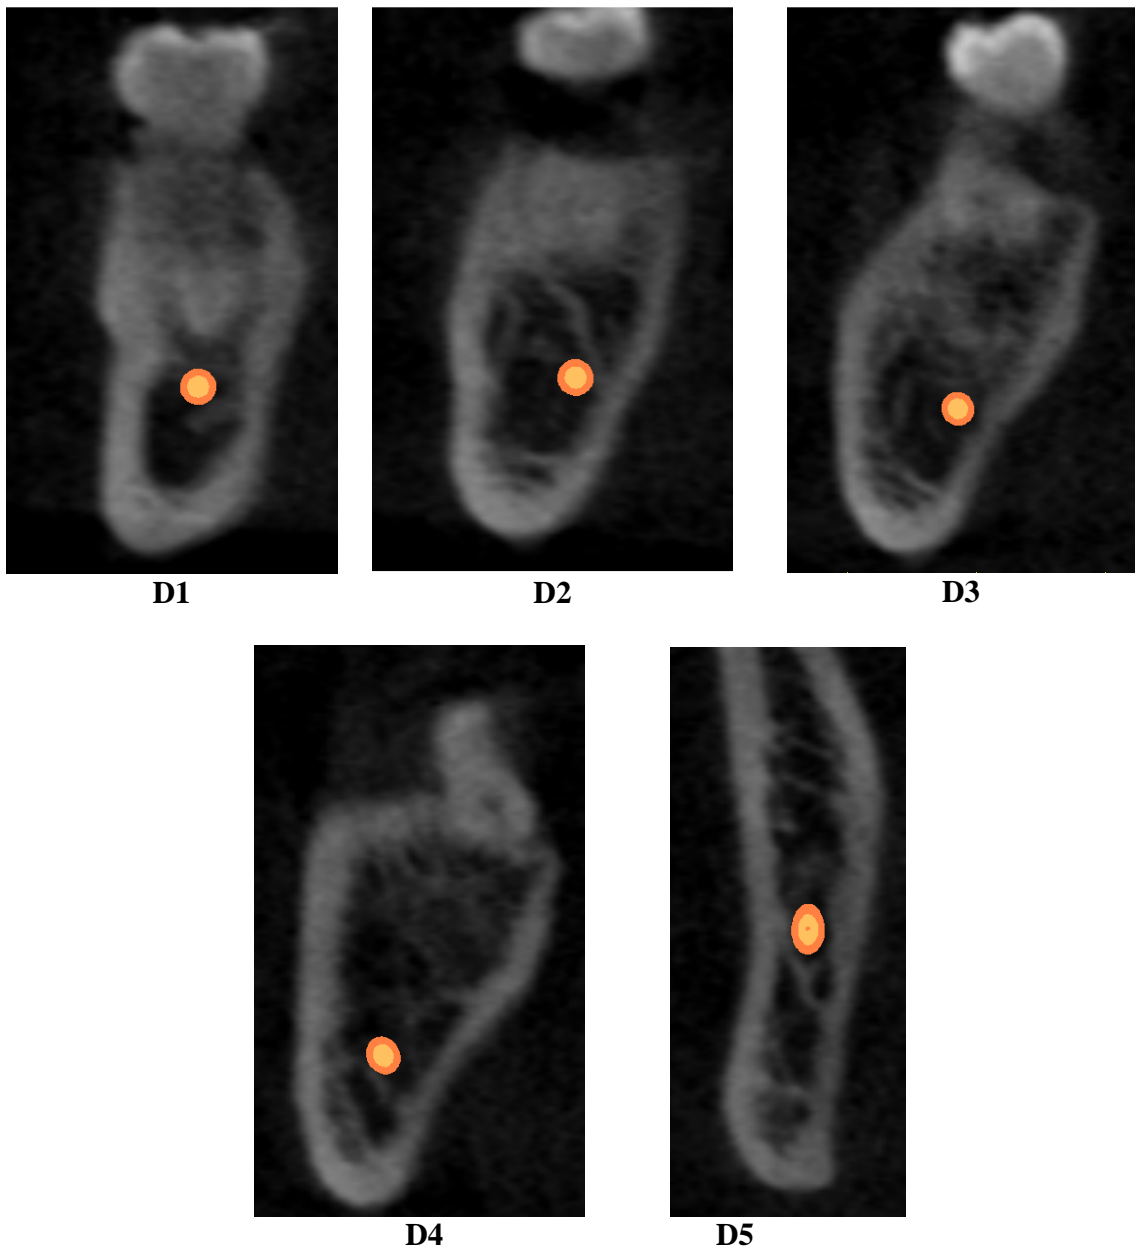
Mandibular canal position at each location considered in this study (D1-D5) - coronal view of CBCT image improved with SimPlant software.
